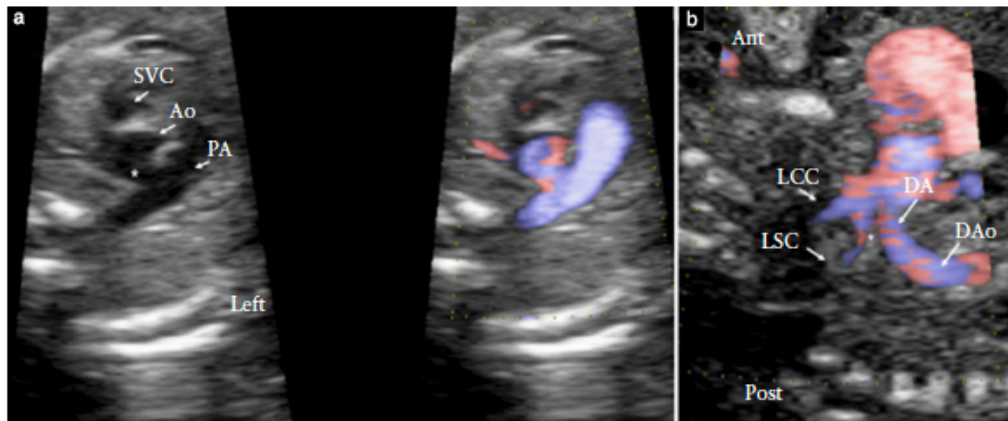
Fetal echocardiography at 21 + 3 weeks' gestation in Case 4, showing: (a) aortopulmonary window (*) at level of three-vessel view, with and without color mapping; and (b) site of interruption of aortic arch (*) in sagittal view. Ant, anterior; Ao, aorta; DA, ductal arch; DAo, descending aorta; LCC, left common carotid artery; LSC, left subclavian artery; PA, pulmonary artery; Post, posterior; SVC, superior vena cava.
